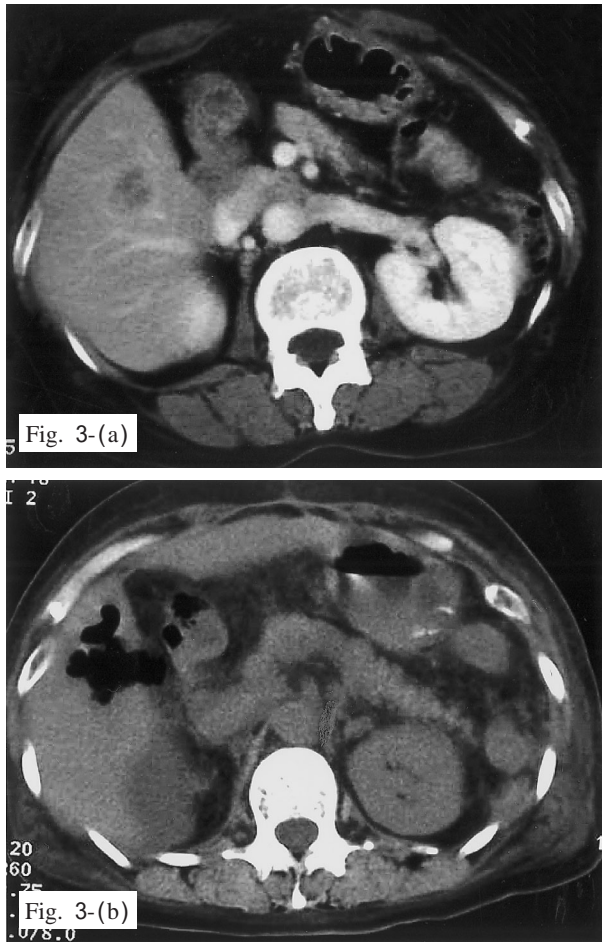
(a) Computed tomography shows a solitary 2.0 cm diameter low-density area in S5 of the liver, (b) Computed tomography shows an abscess formation with gas in S5 of the liver (a week after RFA).
